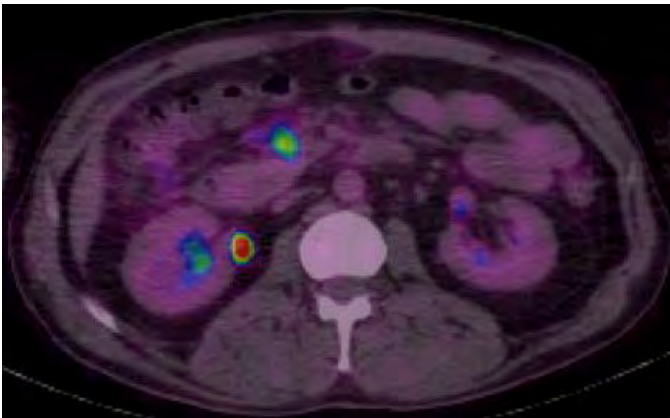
PET-CT with extensive residual lymph node involvement
